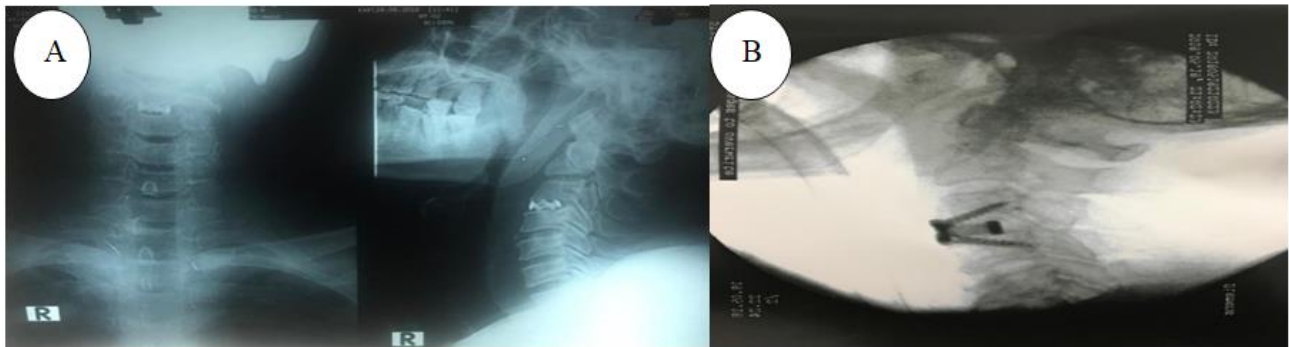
(A): X-ray of the cervical spine showing a mesh cage with plate screw. 5(B): X-ray of the cervical spine showing plate screw.
